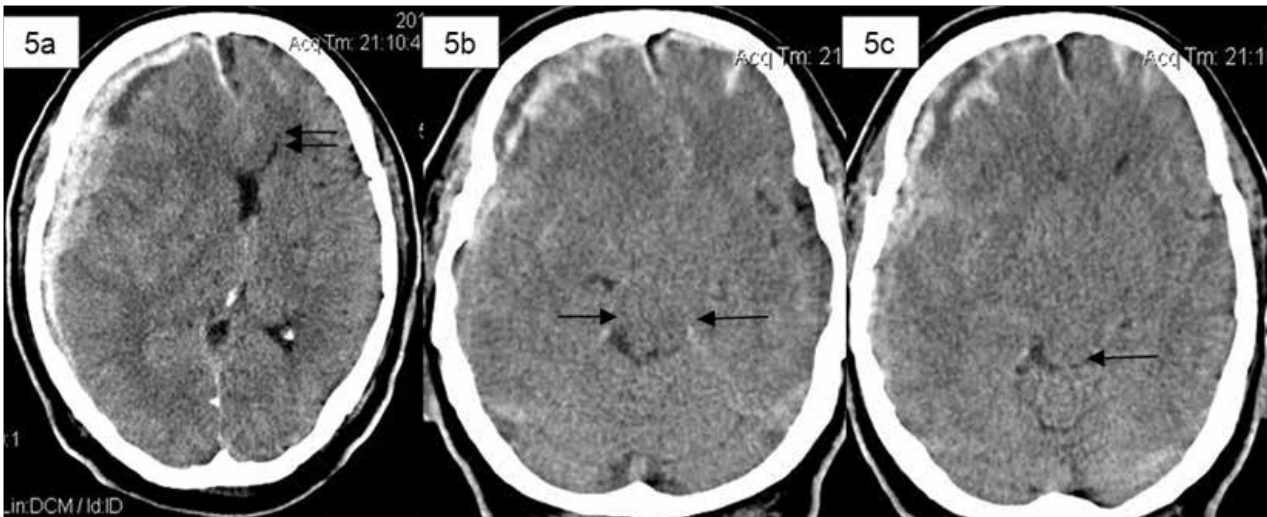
Axial CT scan of acute subdural hematoma along falx cerebri, transtentorial cerebelli, right frontotemporal convexity and diffuse subarachnoid hemorrhage. It shows false-negative finding involving brain herniation.
